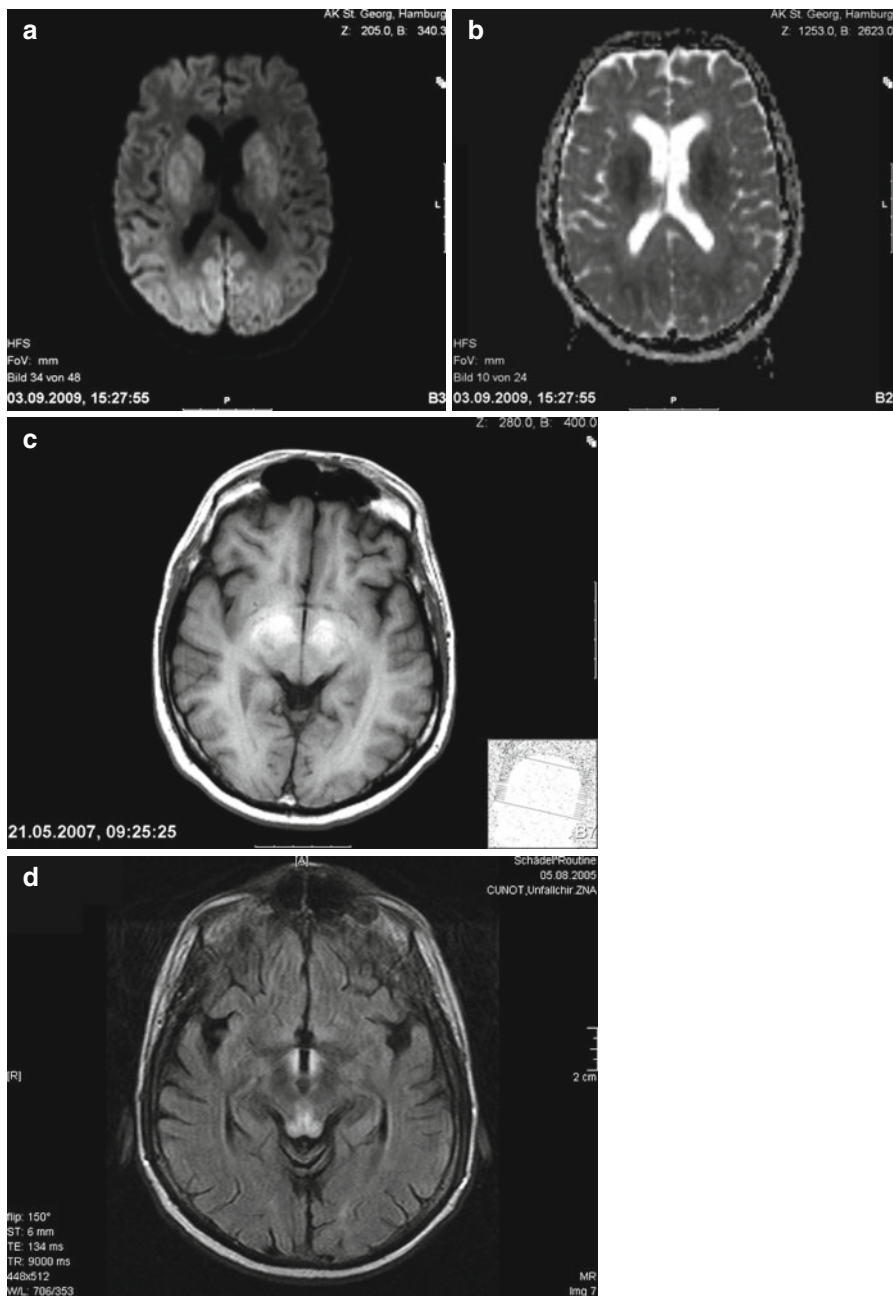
Cytotoxic edema in cerebral grey matter. DWI images (a) and corresponding ADC (b) map in a patient with hypoxic encephalopathy after cardiac arrest. (c) T1-weighted MRI in a case of hepatic encephalopathy. (d) FLAIR images of Wernicke's encephalopathy
